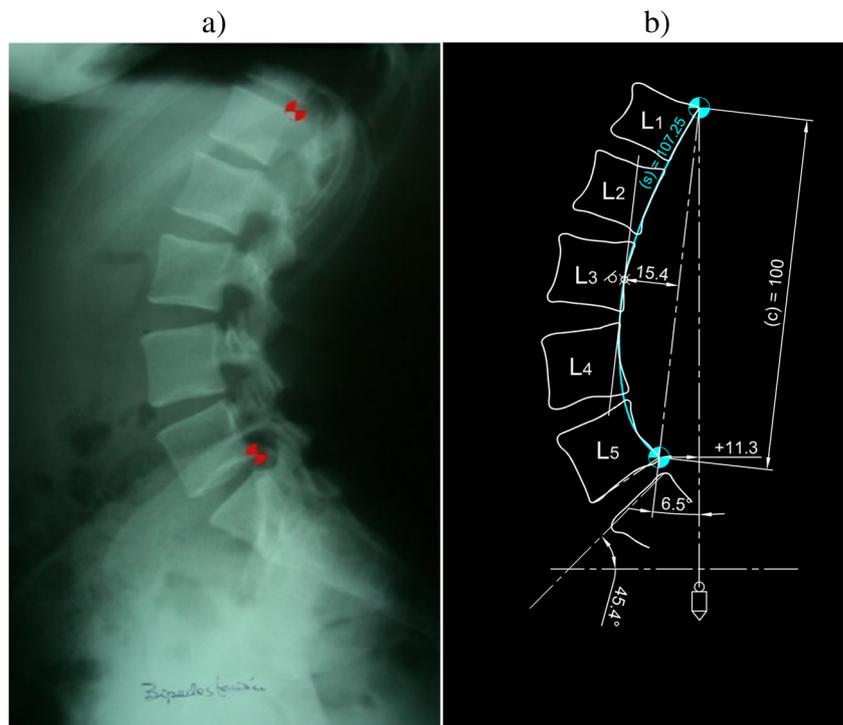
Examples of the results obtained for the measurement of lumbar spine of 17 years male patient in the case of Height of lordosis (4): a) X-ray image; b) Geometrical model (individual 21)
